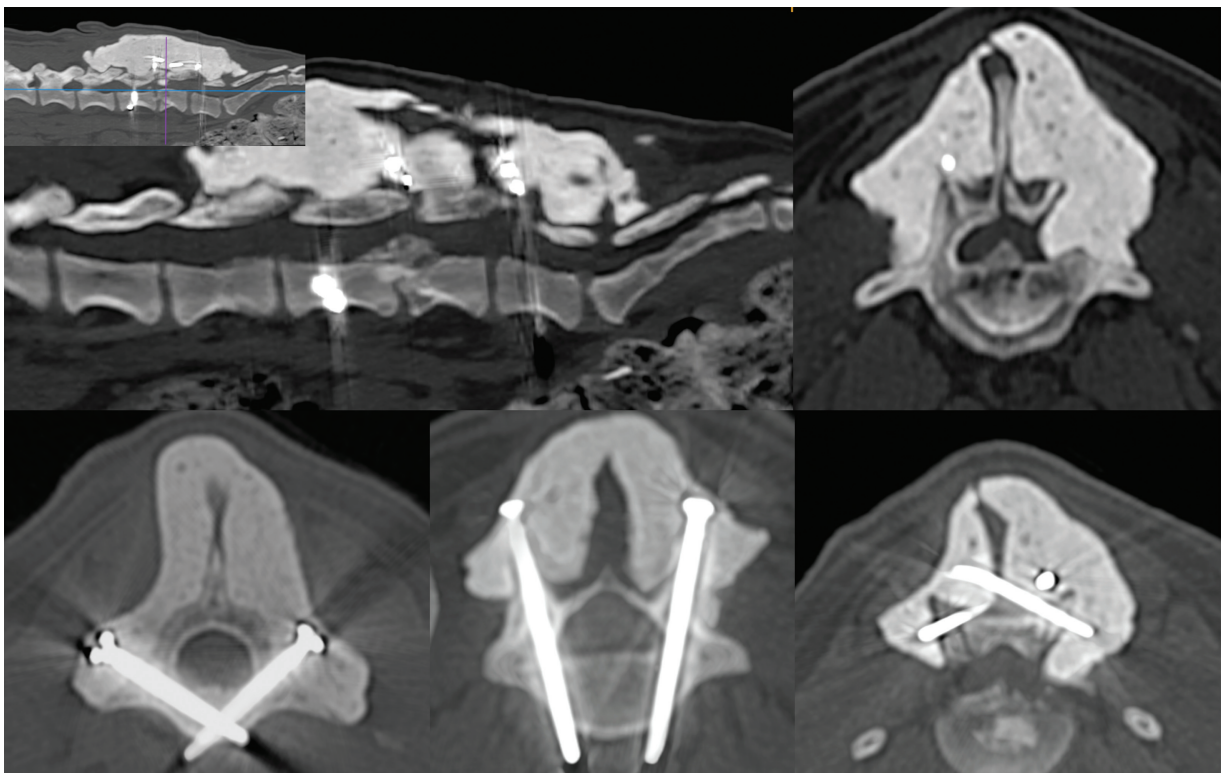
Three-month postoperative computed tomographic multiplanar reconstruction (MPR) sagittal (top left) and transverse plane images at the level of cranial L6 (top right), L5 (bottom left), L7 (bottom middle), and L6/L7 zygapophyseal joints (bottom right), demonstrating progression in healing of the fragmented L6 vertebral body fracture, with incomplete callus formation, less well-defined fracture fragments, and partial bridging of L5 and L6. There is static narrowing of the vertebral canal because of bone fragments and static positioning of polymethylmethacrylate and metallic implants. Insert top left indicates the level of the transverse plane image top right.
